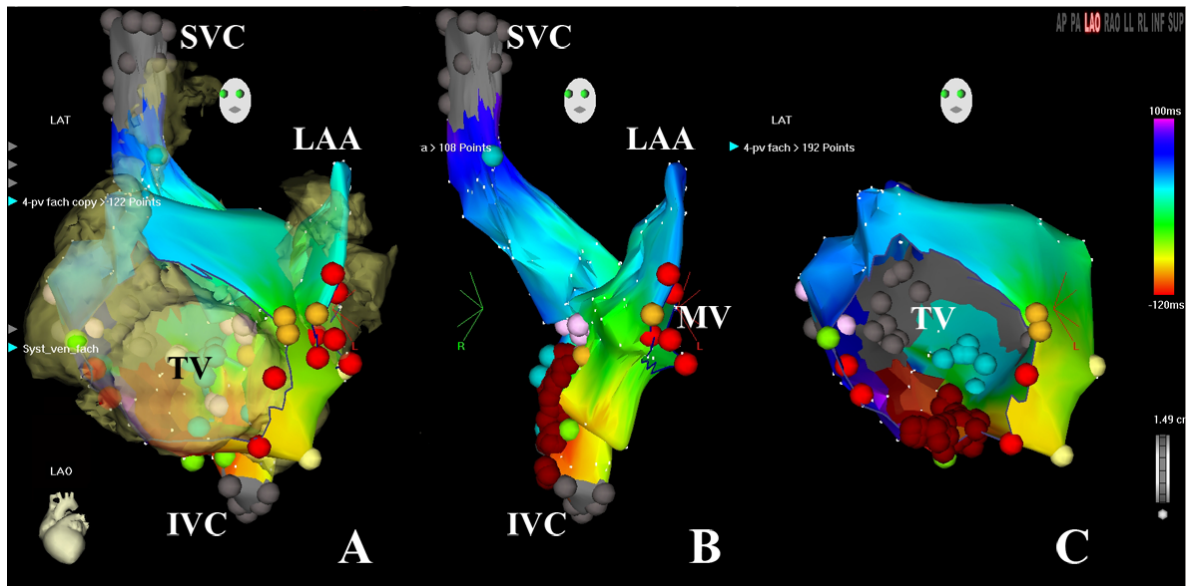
A: Fusion of electroanatomic map and CT-based anatomy after registration using the “merge” function of the CartoMerge® System.
